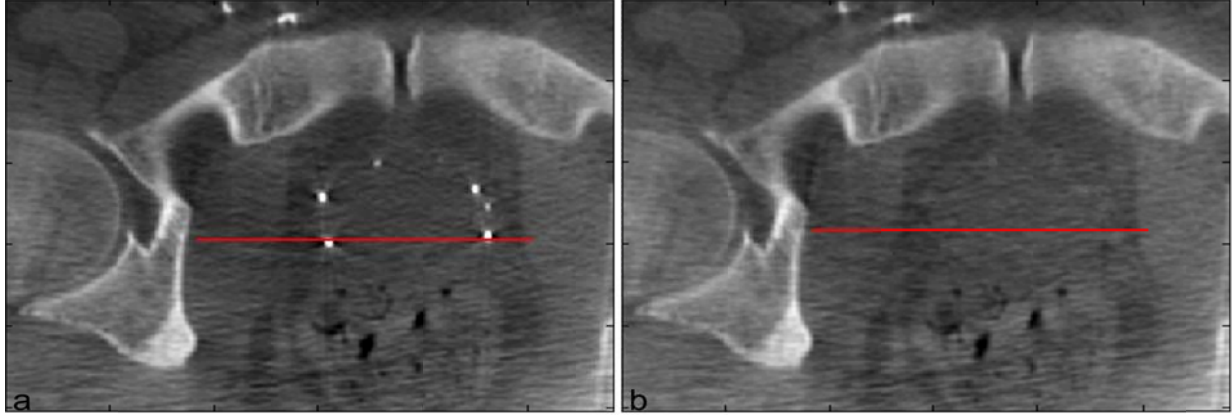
Central slice of the reconstructed CBCT image-ROI of Patient I, (a) without seed projection removal showing streaking artifacts, and (b) with projected seed image suppression showing significant streak reduction; some residual artifact remains because only about 30% of seeds could be segmented in the right/left lateral projections.
